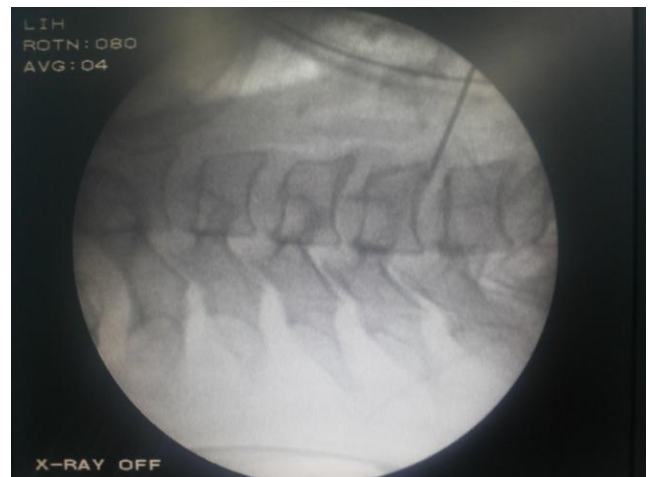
Radiological X-Ray view by C-Arm with needle marker
